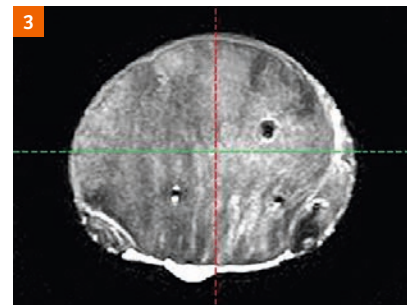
MRI of the pork loin with two markers of 0.5% and one of 2.5% iron content.
